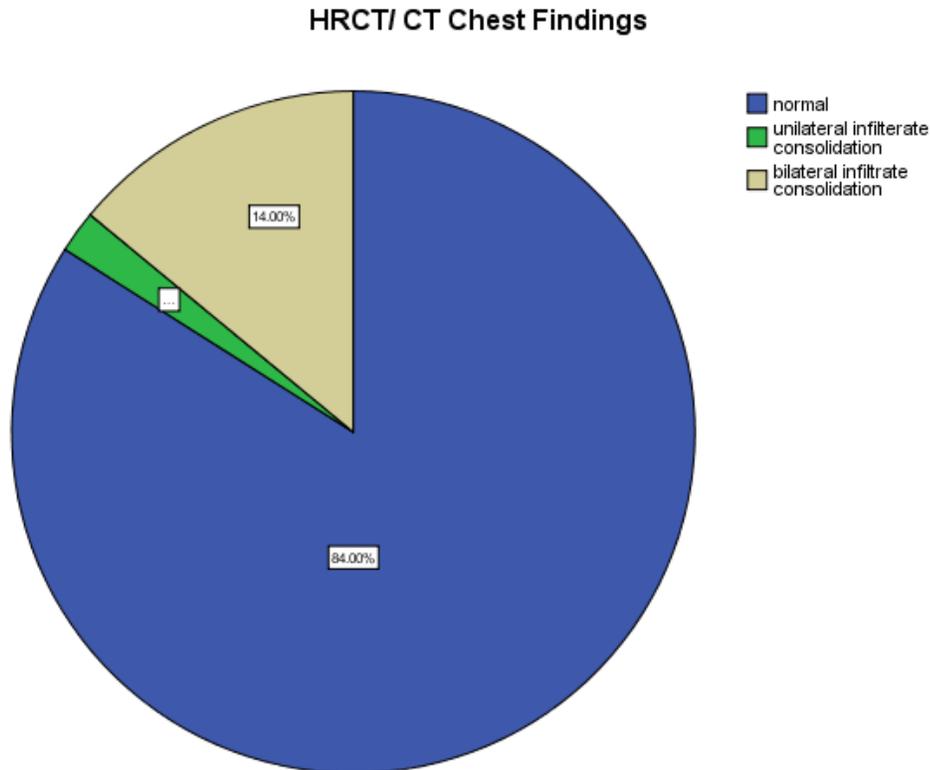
Pie charts showing the percentages of HRCT/CT chest findings.
